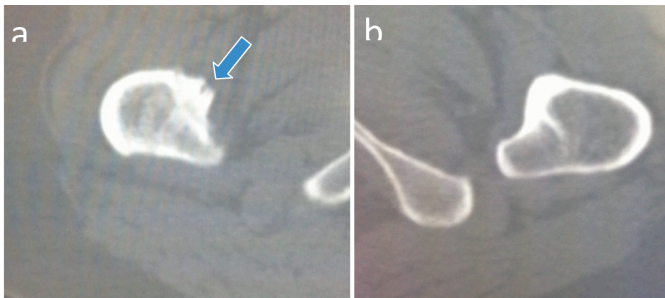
CT axial scan (a) showing irregularity of the lesser trochanter and (b) demonstrating normal lesser trochanter.
